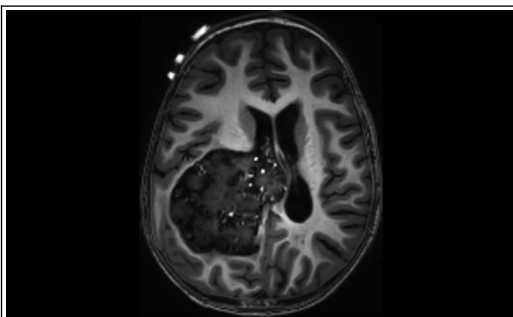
T1-weighted MRI brain
